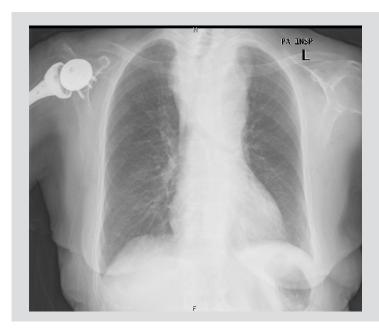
Chest X-ray showing an enlargement of the mediastinum
